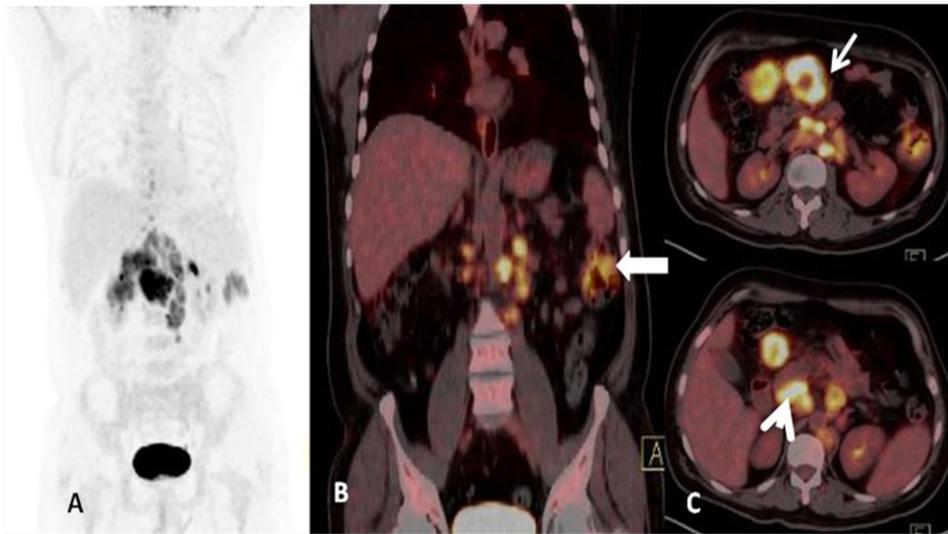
A: Maximum intensity projection image, B: Coronal fused PET/CT and C: Transaxial fused PET/CT images reveal abnormal tracer accumulation in the descending colon (thick arrow) and multiple enlarged nodes in the mesentery (thin arrow) and peripancreatic (arrowhead) locations showing avid FDG uptake.
